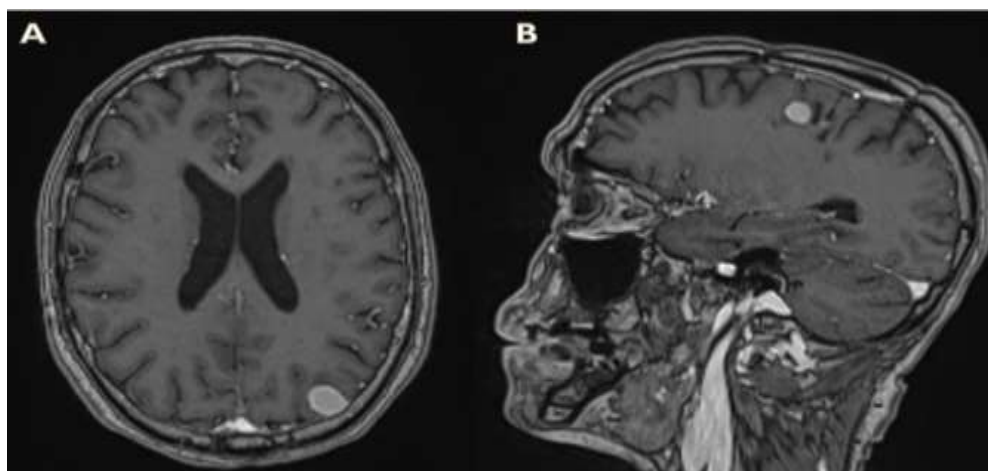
Enhancement pattern: Axial (A) and Sagittal (B) T1-weighted images after gadolinium injection showing intense, homogeneous enhancement of the lesions, mimicking the appearance of extra-axial dural tumors
